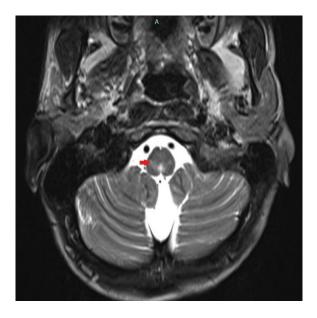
Axial T2W MRI brain with hyper-intense signals at cervico-medullary junction at the obex.
